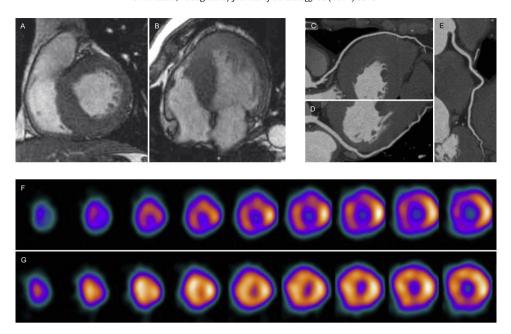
Representative case of subendocardial ischemia in hypertrophic cardiomyopathy. Cardiac magnetic resonance shows asymmetric septal hypertrophy (Panel A, short-axis; Panel B, long-axis) in a 61-year-old man with chest pain on exertion. Coronary computed tomography angiography shows no atherosclerotic stenosis in the left descending coronary artery (Panel C), the left circumflex coronary artery (Panel D), and the right coronary artery (Panel E). Notably, exercise-induced transient cavity dilation is apparent on short-axis slices of thallium-201 scintigraphy after exercise (Panel F), compared with at rest (Panel G), features consistent with left ventricular subendocardial ischemia
